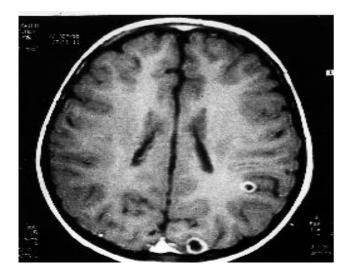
MRI T1 enhanced with gadolinium showing two cysticerci without surrounding edema.
